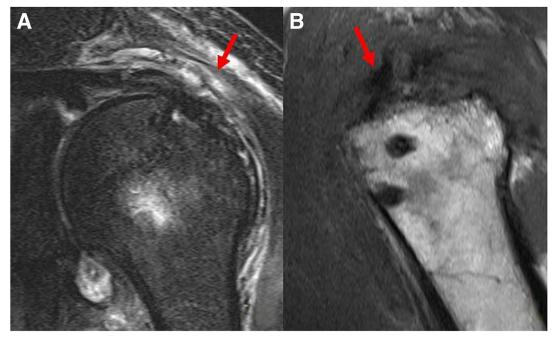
In the postoperative oblique coronal and sagittal MRI, the torn articular surface tear is restored, and the restoration of the rotator cuff defect is achieved by augmentation with the biceps tendon (arrow).
